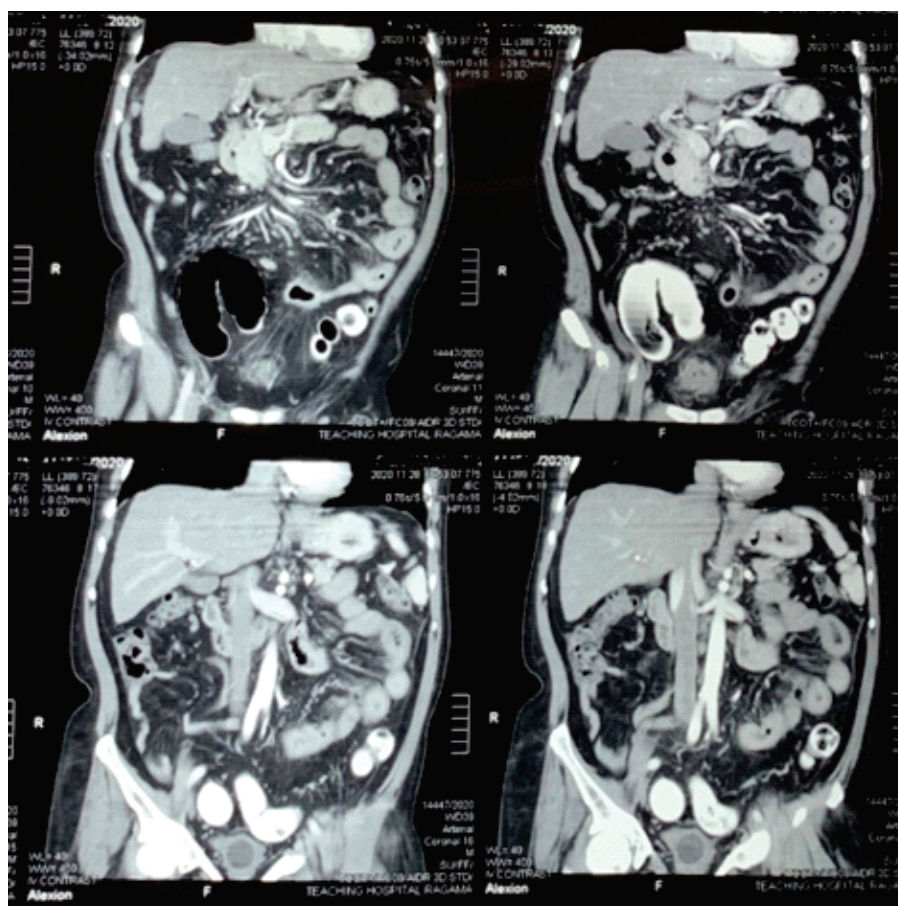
Contrast Enhanced computed tomography of abdomen sagittal and coronal views
